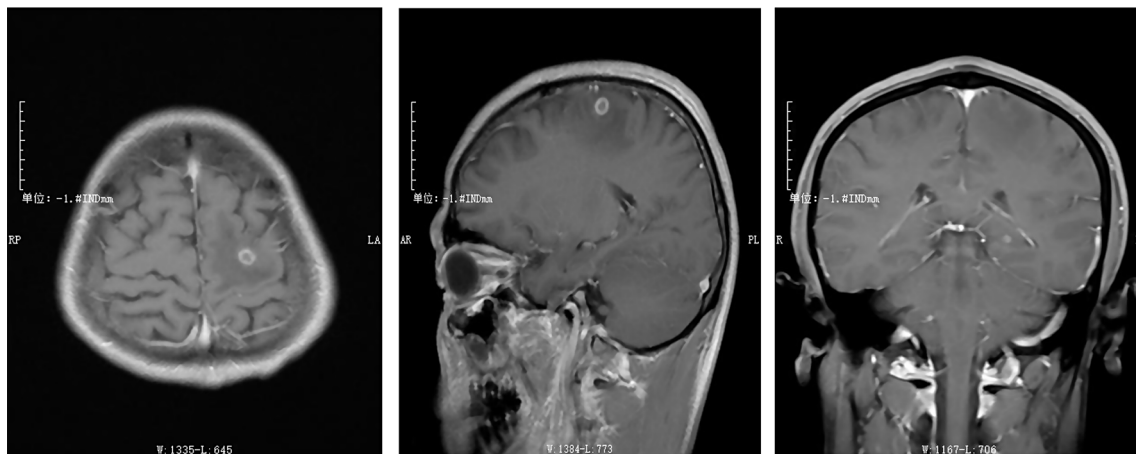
Head MRI T1-weighted images. On the head MRI T1-weighted imaging with contrast enhancement, a ring-enhancing lesion is observed in the left frontal lobe and left hippocampus. Patchy edema is visible surrounding the lesion in the left frontal lobe
